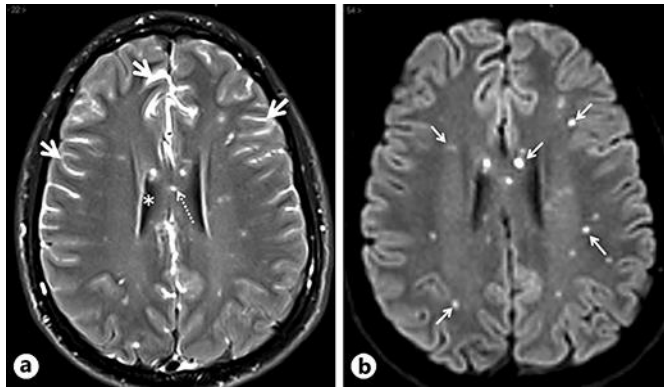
Magnetic resonance workup. a Contrast-enhanced transverse fluid-attenuated inversion recovery view showing numerous hyperintense foci within brain parenchyma, i.e. within corpus callosum (dotted arrow), together with strong enhancement of peripheral subarachnoid spaces (arrows) contrasting with normal signal suppression of intraventricular CSF (asterisk). This unusual feature assessed intense meningeal inflammation with subsequent massive leakage of contrast agent molecules within surrounding CSF. b Transverse diffusion-weighted (DW) view in similar slice location as a with b factor at $1,000 \text{ mm}^2/\text{s}^2$ showing punctate foci seen on previous images as hyperintense foci of restricted water diffusivity with strongly decreased apparent diffusion coefficient (ADC) values (parametric ADC map not shown). Synchronous DW positivity of all lesions closely matched the synchronous enhancement of all lesions seen on post-contrast T1-weighted views (not shown).
